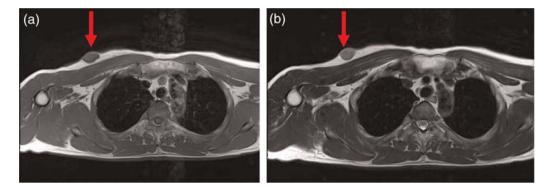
MRI scan after 7 years of follow-up demonstrated a small subcutaneous mass lesion. The signal from both T1WI (a) and T2WI (b) was almost the same compared to the ordinary mass lesion
